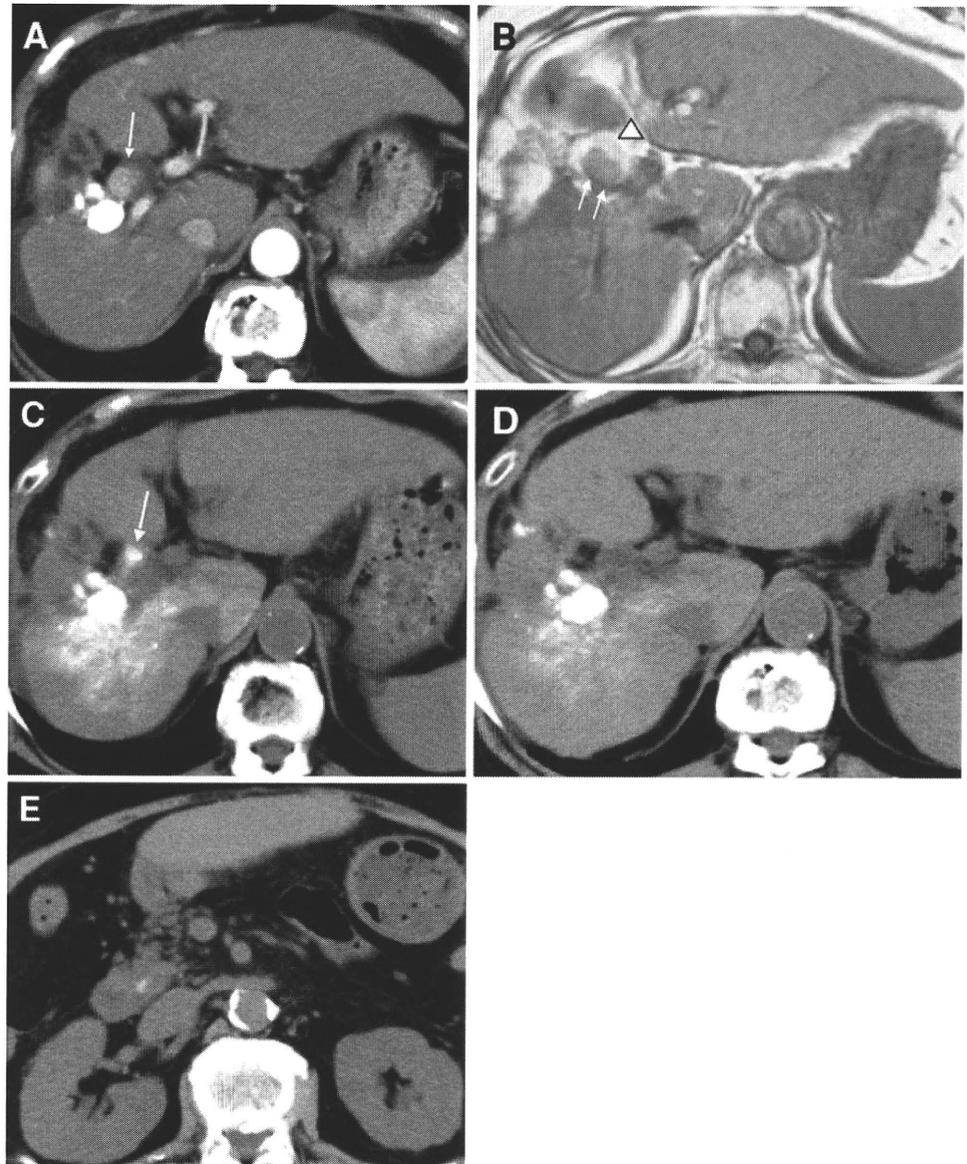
Case no. 2. A Arterial-phase CAT shows an intraductal tumor thrombus in the right hepatic duct (*arrow*). B Axial T1-weighted MRI demonstrates the intraductal tumor (*arrows*) and hemobilia (*arrowhead*). C Unenhanced CAT 7 days after TACE shows dense iodized oil accumulation in the tumor and intraductal tumor thrombus (*arrow*). The tumor thrombus has shrunk slightly and migrated distally. D Unenhanced CAT 10 days after TACE shows the disappearance of the intraductal tumor thrombus. E At the bottom of the CAT image shown in (D), the tumor thrombus has sloughed into the common bile duct
